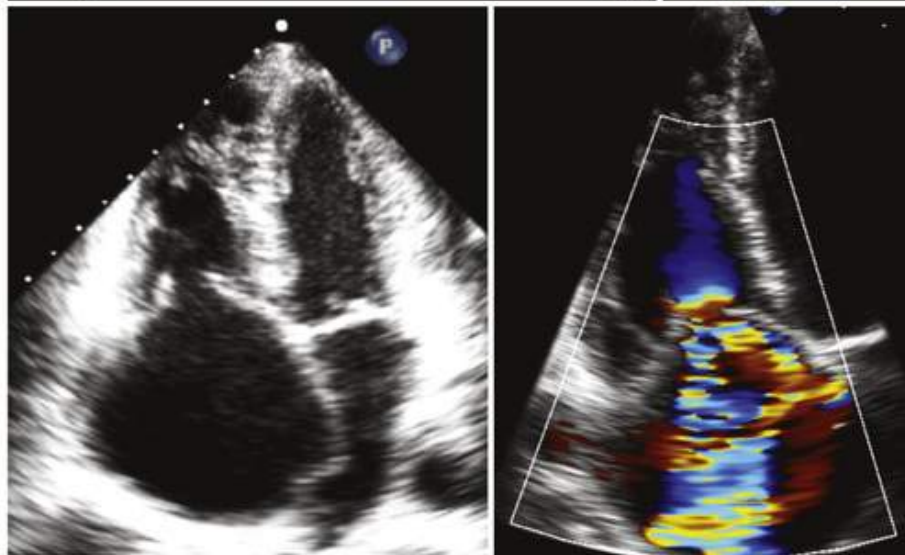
A typical 2D echocardiographic image of severe tricuspid regurgitation that is commonly encountered in a carcinoid tumor. There is poor coaptation of the tricuspid valve leaflets with tethering, which is seen in many instances.
